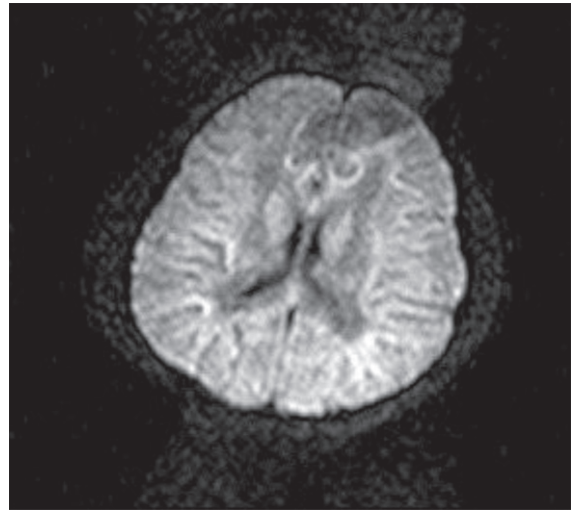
Bilateral ischemic infarcts are shown in basal ganglia and parietooccipital cortex in cranial MR imaging with diffusion weight scene.
